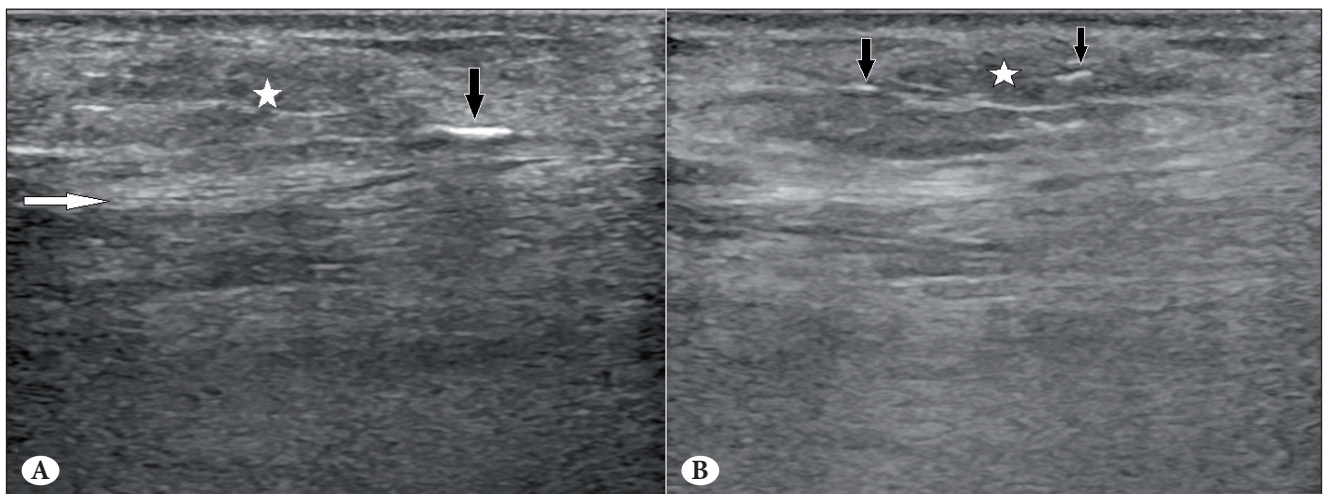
A,B) Transverse (A) and longitudinal (B) sonograms imaging at the crural level reveal an edema zone (asterisk), including millimetric-scale linear calcifications (black arrows) in the subcutaneous fat images that cause undulations toward the depths of the fascial plans.
